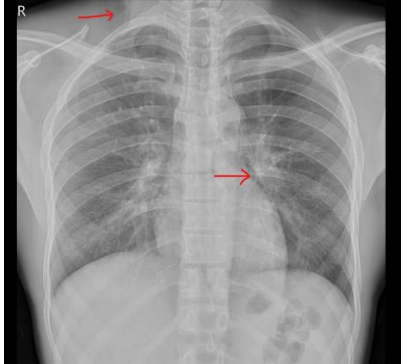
Plain chest radiograph demonstrating pneumomediastinum (sharp line of increased lucency outlining left heart border - lower arrow) and subcutaneous emphysema (increased lucency visualized in right lower neck - upper arrow).
